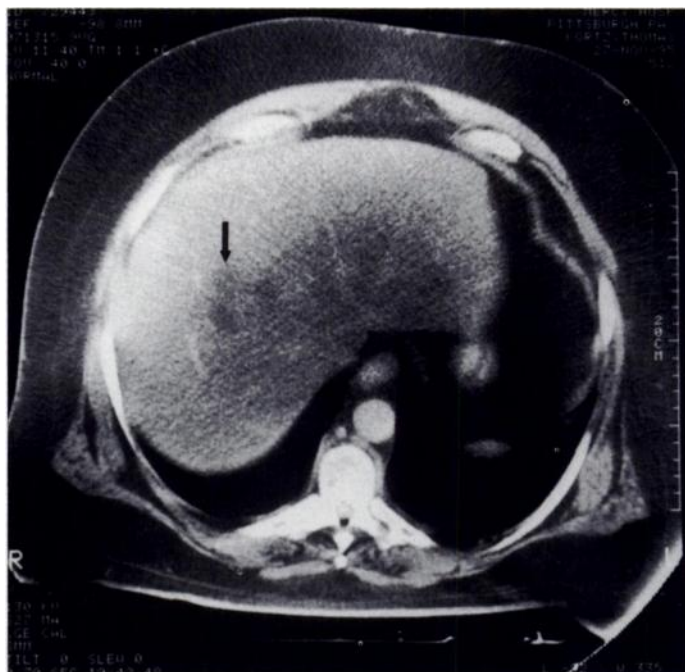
The initial contrast-enhanced CT showed a subtle low-density lesion in the right-middle hepatic lobe consistent with early hepatic abscess.
